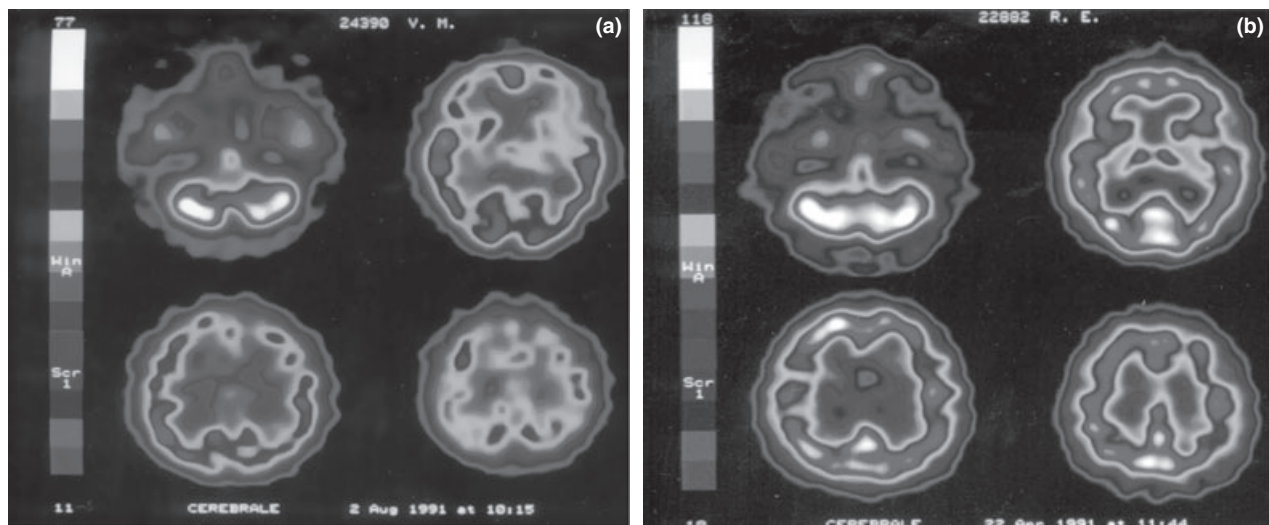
99mTc-HM-PAO single-photon emission computed tomography shows residual defect 1 year after heart transplantation (a) compared to control (b).
